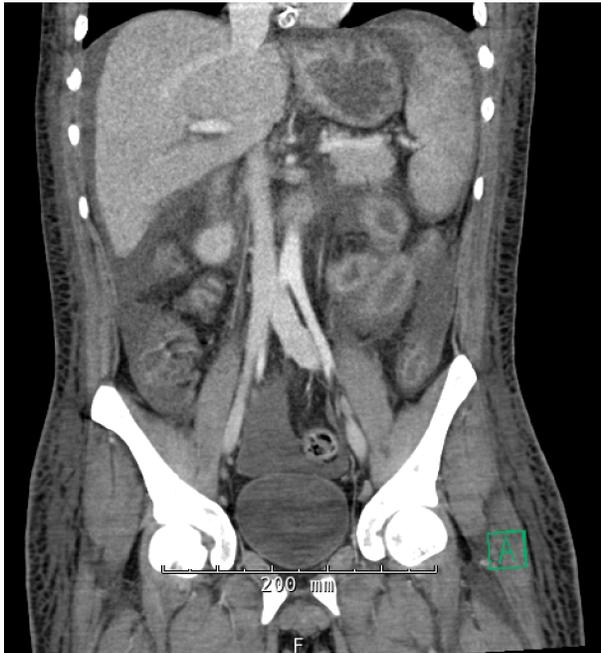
Computed tomography of the abdomen and pelvis showing splenomegaly, perisplenic ascites, and patchy perfusion of bilateral kidneys
